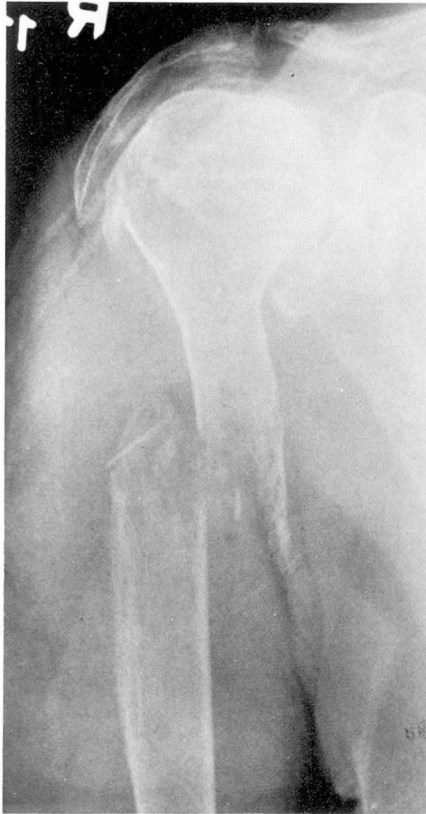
Roentgenogram, right humerus (case 19); lytic metaphyseal lesions associated with a pathological fracture.
